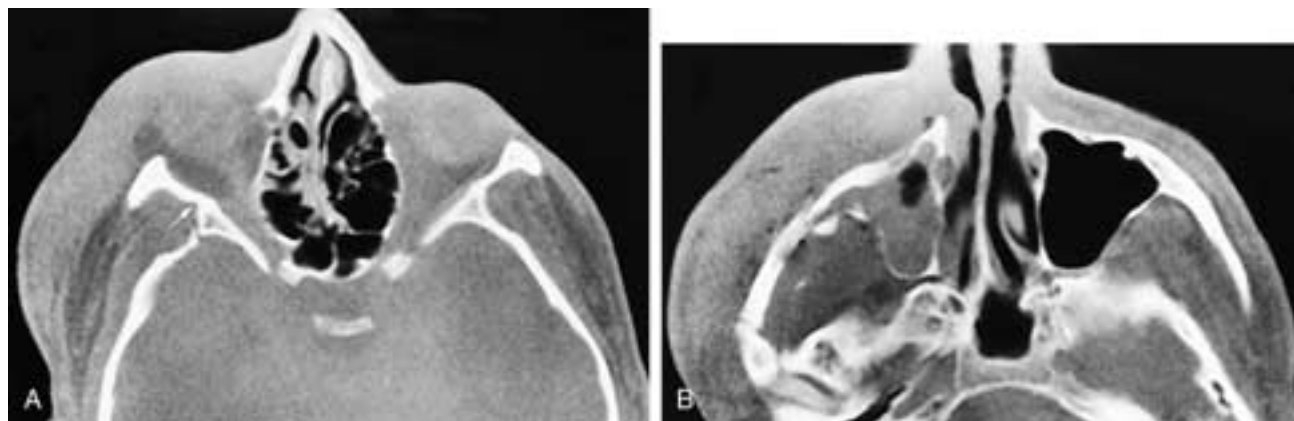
Axial CT scans through the orbit (A) and the zygomatic arch (B) show a right zygomatic fracture with posterior displacement and clockwise (medial) rotation of the zygoma. The site of the zygomatico-frontosphenoid fracture is also seen (*arrow* in A).
